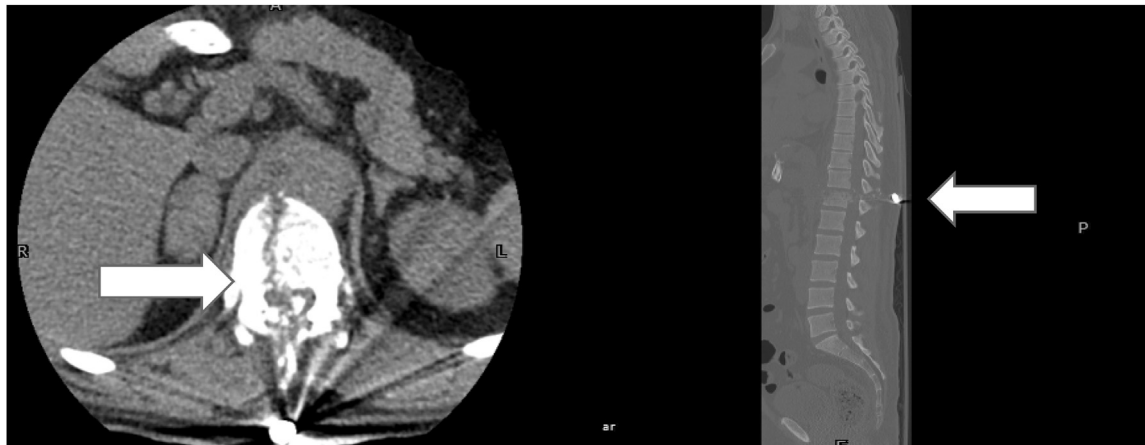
a shows the CT spine with a burst fracture of the D12 vertebra with complete cord transection, Fig. 2.b shows a sagittal section of the CT spine with the bullet at the tip of the spinous process of the D12 vertebra.
